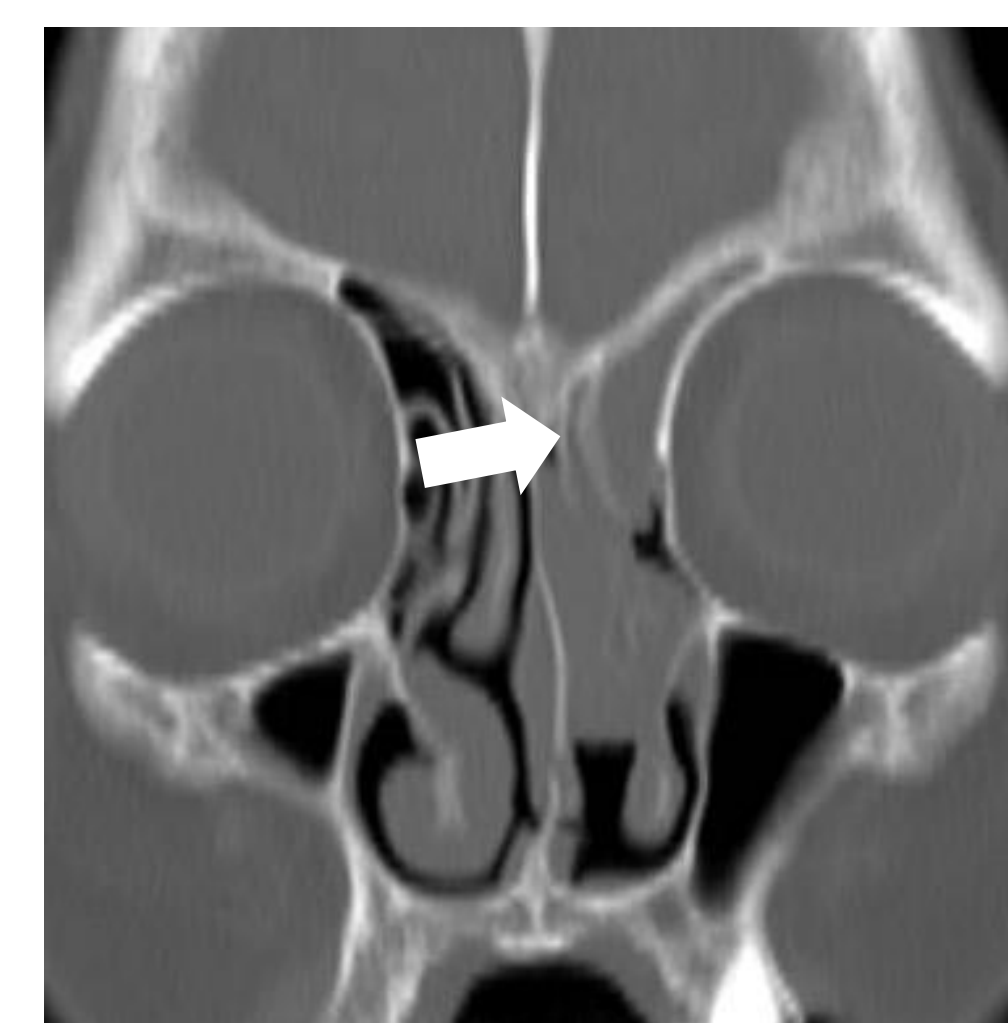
Plane CT of case2
